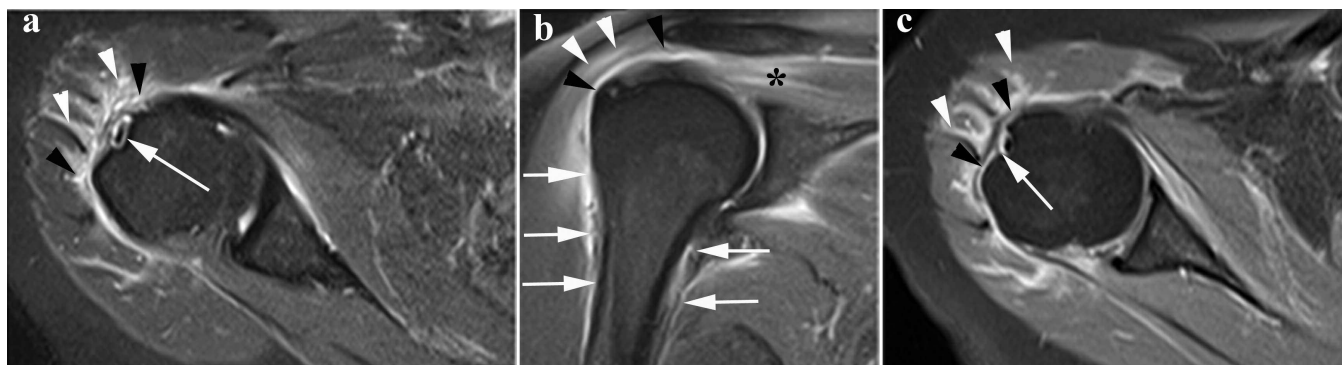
MRI in idiopathic inflammatory myopathies. A. Axial short-tau inversion recovery (STIR) sequence. High signal in the deep lateral part of the deltoid muscle (white arrowheads), subdeltoid bursa (black arrowheads), and synovium (white arrow), showing edema and inflammatory changes. B. Coronal STIR sequence. High signal in the deltoid muscle (white arrowheads), supraspinatus muscle and tendon (*), and subdeltoid-subacromial bursa (black arrowheads), extending around the proximal humeral shaft (white arrows), showing edema and inflammatory changes. C. Axial T1 fat saturation after intravenous gadolinium injection. Enhancement of the deep lateral part of the deltoid muscle (white arrowheads), subdeltoid bursa (black arrowheads), and synovium (white arrow), evidence of lesions of myositis, bursitis, and synovitis.
